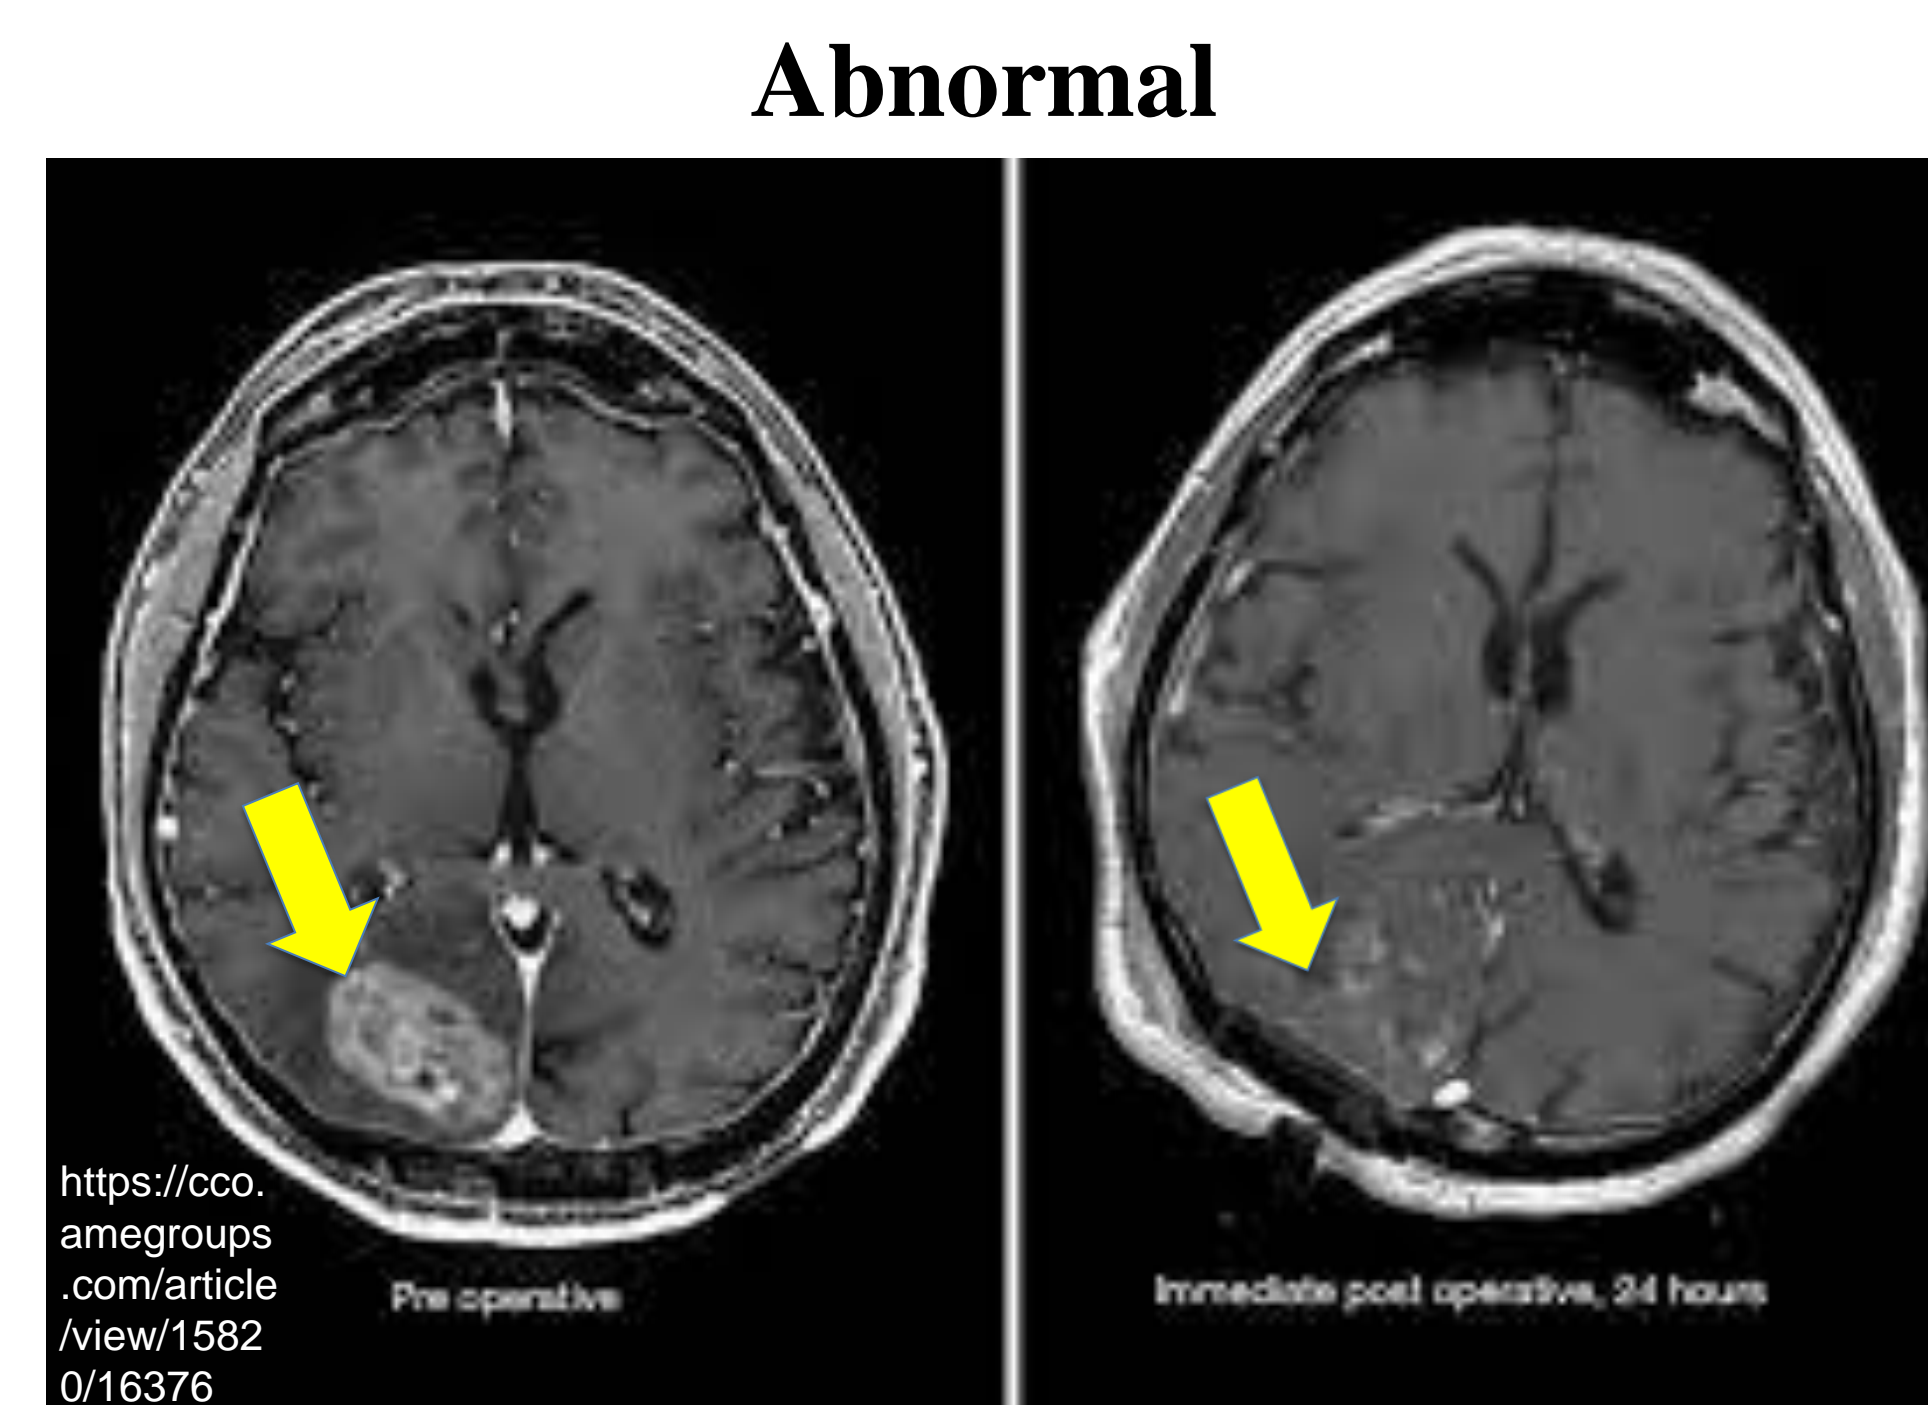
Axial MR images of a brain with a glioblastoma pre-operative and 24-hour post-operative (see arrows)
